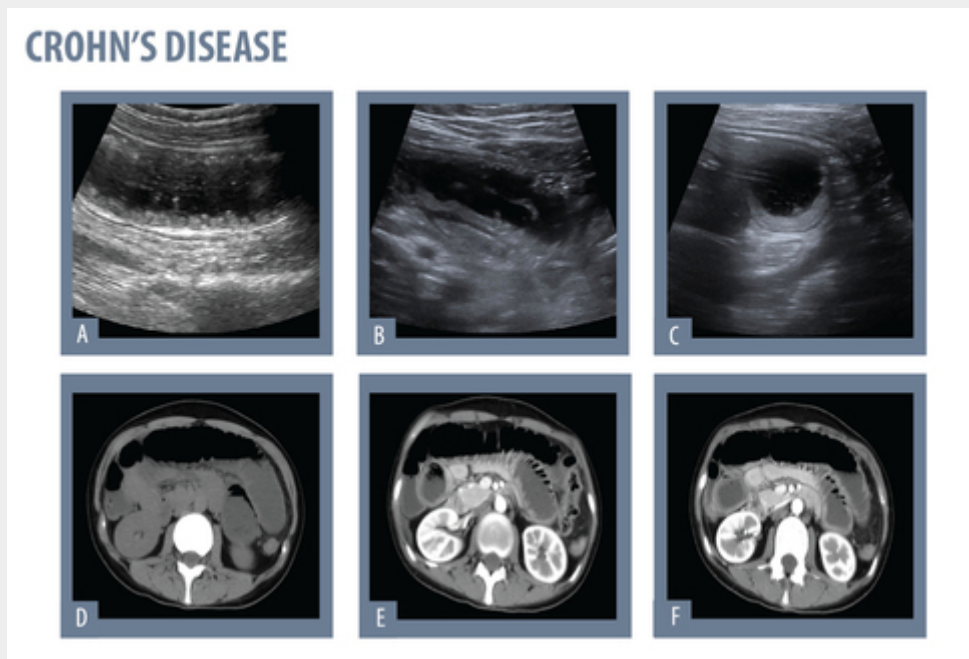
26 year-old patient presenting with RLQ pain, with a recent history of weight loss and diarrhea. On US (A,B, C) there were dilated bowel loops, with wall thickening and fluid-filled. On CT (D,E,F) there was apparent jejunum, ileum and ascending colon distention, and densification of the pericolic fat. She was admitted and diagnosed with Crohn's disease.
